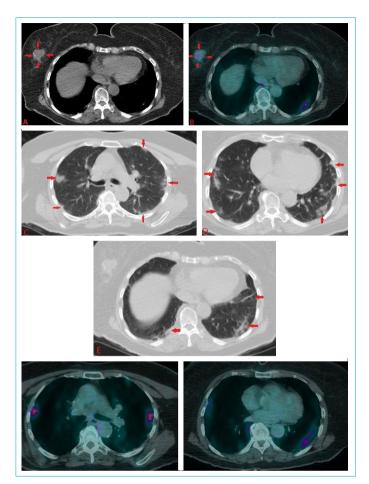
A 66 -year-old female with breast cancer. (a) Axial non-contrast chest CT and (b) PET CT show a mass in right breast (arrows). (c-e) CT shows bilateral , ground-glass infiltrates with well-defined borders, predominantly peripheral and localized in lower lobe (arrows). (f,g) PET CT shows increased [¹⁸F]FDG uptake (SUV max 3.9).
